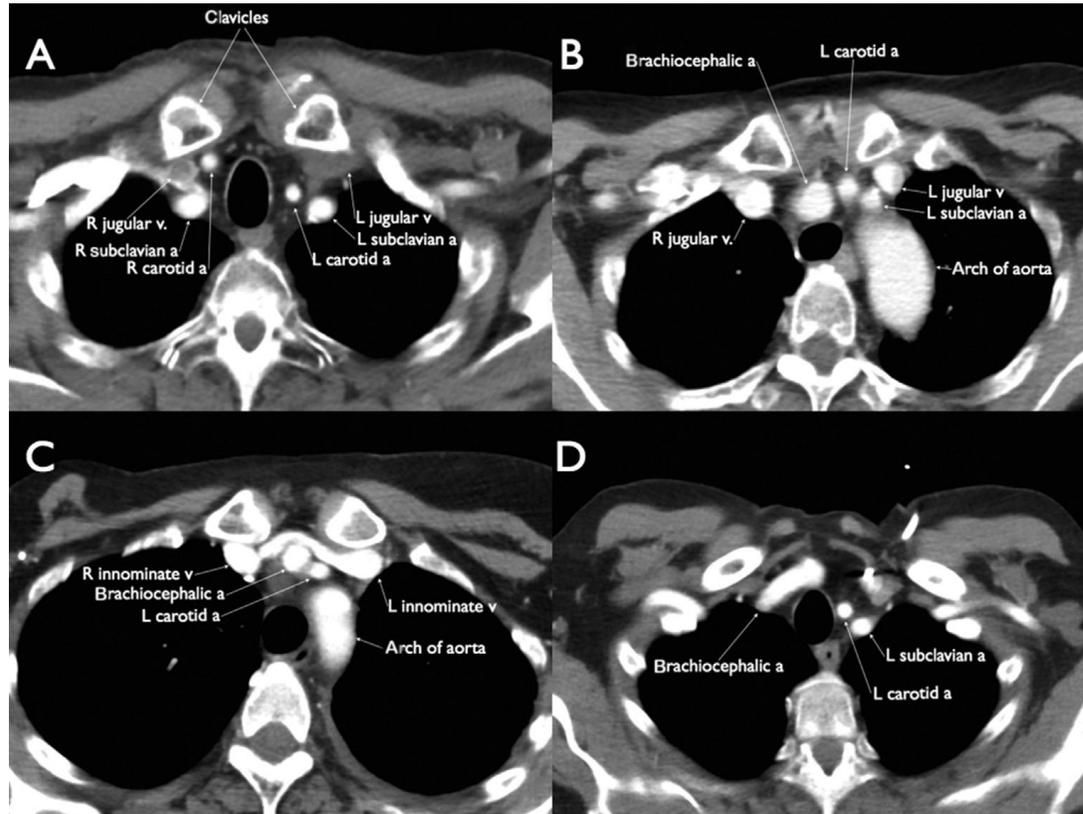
Computed tomography scans of the thoracic region. (A) Normal anatomy, with no major vessels anterior to the trachea in the suprasternal notch; (B) Patient with brachiocephalic artery and part of the left carotid artery anterior to the trachea in the suprasternal notch; (C) Patient with both left innominate vein and brachiocephalic artery anterior to the trachea in the suprasternal notch; and (D) Patient with brachiocephalic artery crossing the trachea 25 mm above the suprasternal notch. a, artery; L, left; R, right; v, vein.
